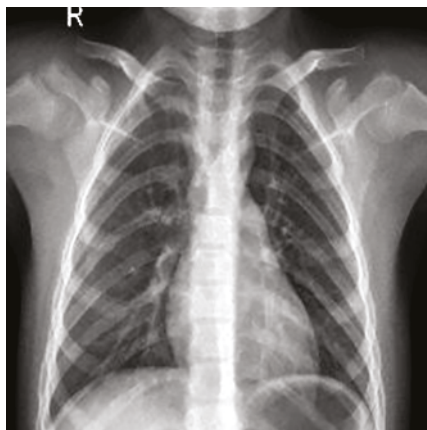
Sample X-ray image without signs of disease [17]
